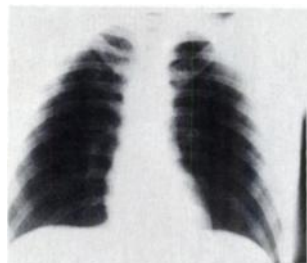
Chest radiograph on day of injury. No abnormalities of lungs or skeletal structures were observed.
